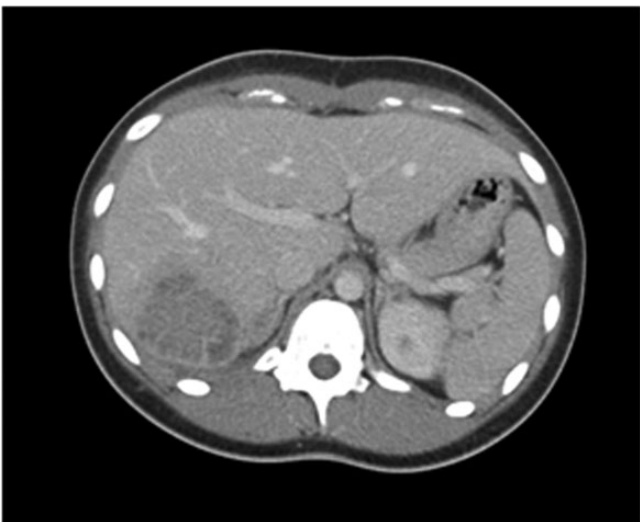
CT scan showed a large multi-septated liver abscess in the right lobe of the liver (Case 2).
